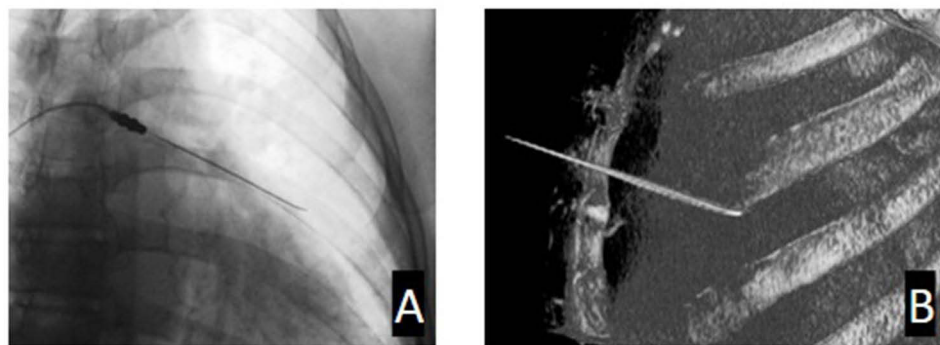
Cannula advancement beneath the rib prior to detection of intrathoracic misplacement. (A) X-ray of the cannula position. (B) 3D CT of the cannula position.
